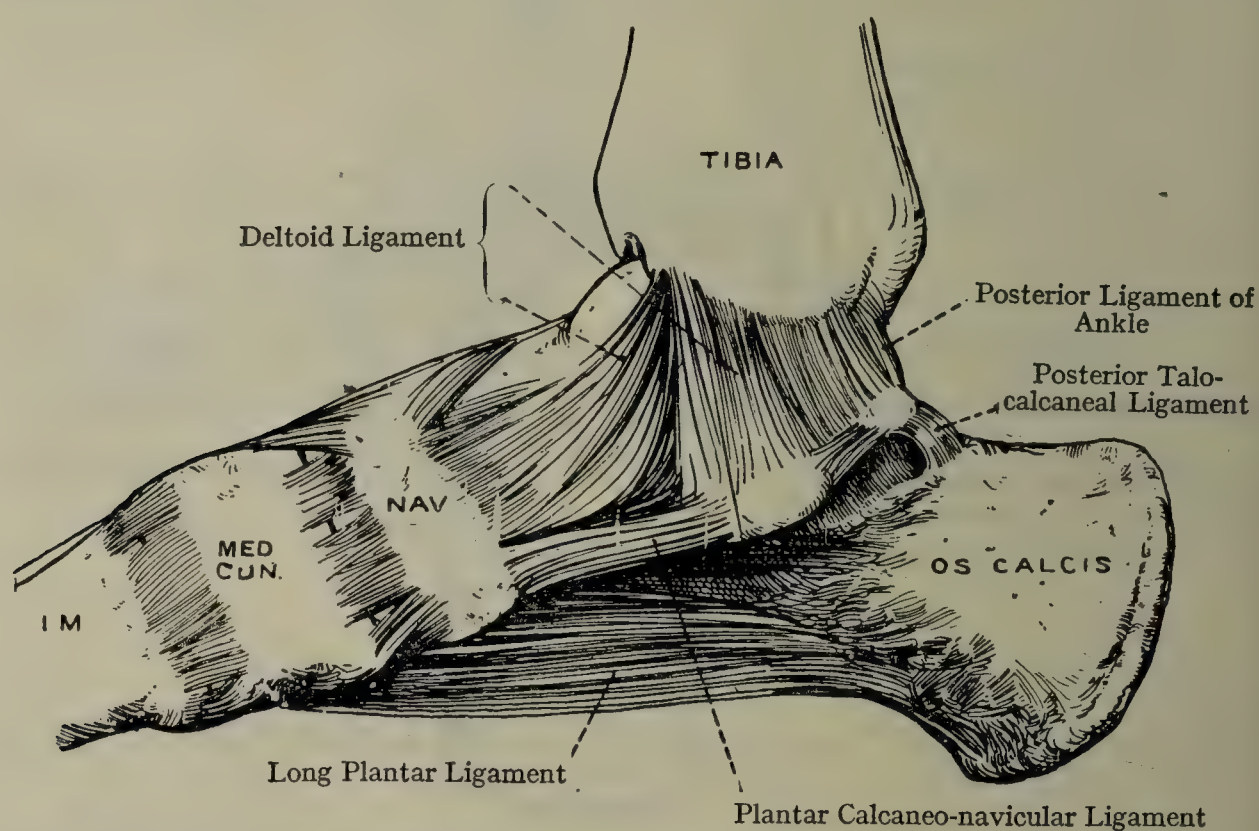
LIGAMENTS OF THE RIGHT FOOT (MEDIAL ASPECT).
